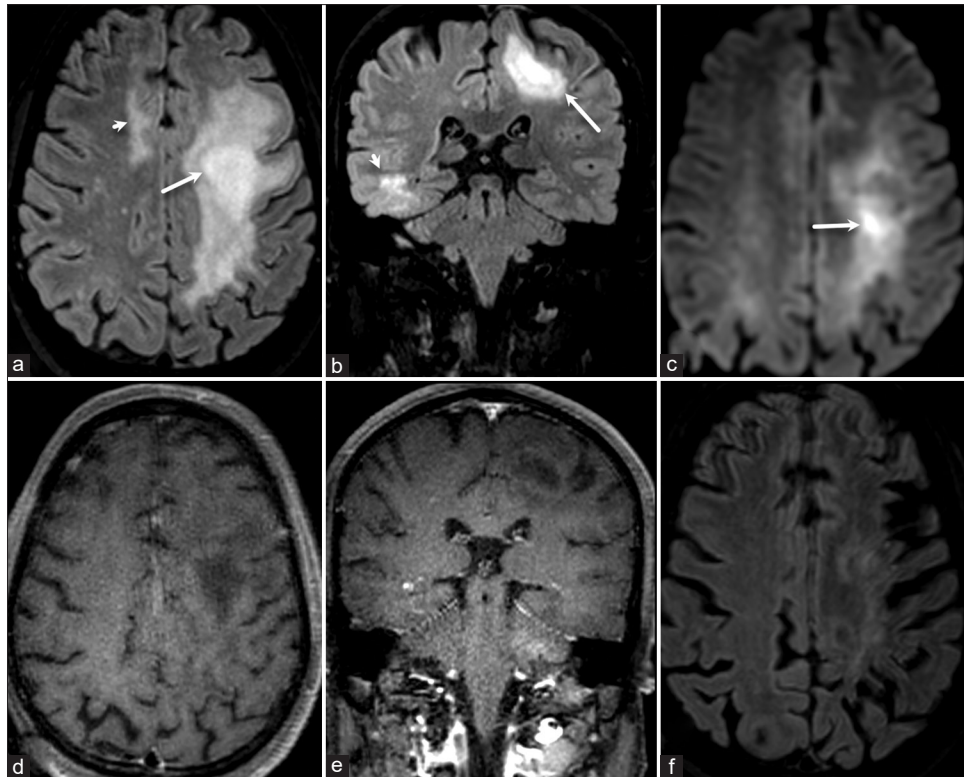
Axial (a) and coronal (b) FLAIR images show multiple lesions limited to the white matter in the left frontal, right frontal (short arrow in a), and right posterior temporal (short arrow in b) with a core of more hyperintensity in left frontal lesions (arrows in a and b). Focal diffusion restriction (arrow in c) is seen within the core of the left frontal lesion in the diffusion-weighted image (c). No enhancement is seen in post-contrast axial (d) and coronal (e) T1-Wis. Follow-up FLAIR image (f) done after a year shows complete resolution of lesions with atrophy
